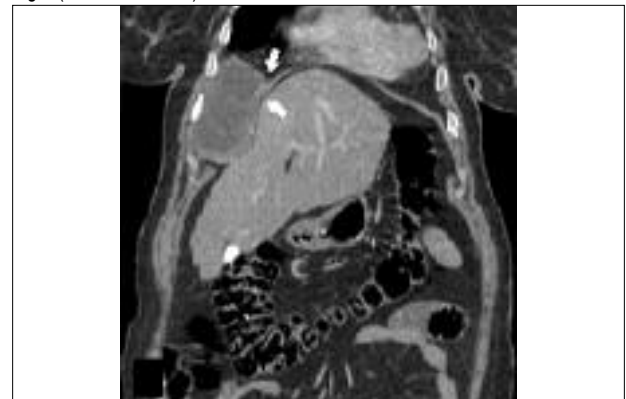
Coronal CT showed cystic lesion with wall calcifications that formed an obtuse angle with the right hemidiaphragm (white arrows) and displaces the liver inferiorly.
